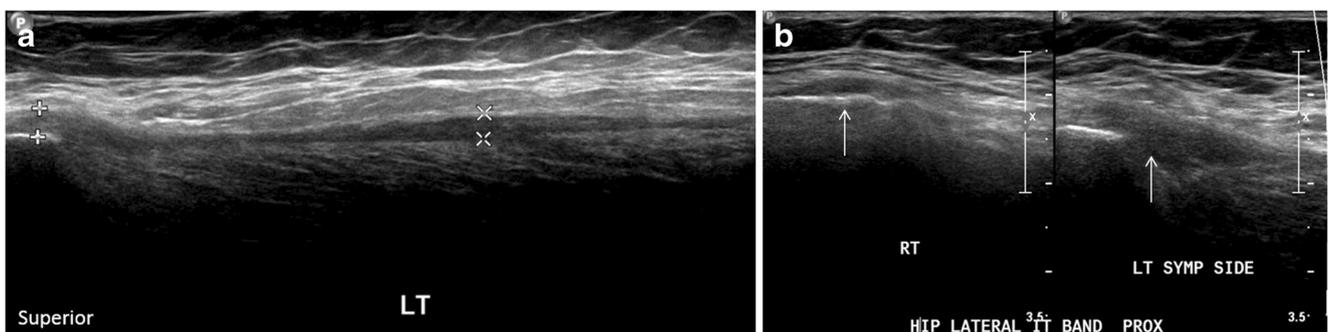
A 45-year-old female with left hip pain. a Longitudinal ultrasound demonstrates diffuse thickening and irregularity of the proximal iliotibial band, corresponding to the site of the patients’ pain as elicited by application of transducer pressure over the proximal attachment. b
